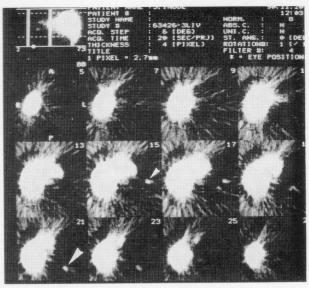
SPECT image of the upper abdomen. Normal hepatic uptake and abnormal spotty uptake (small and large arrowhead) in the left abdomen is observed.
